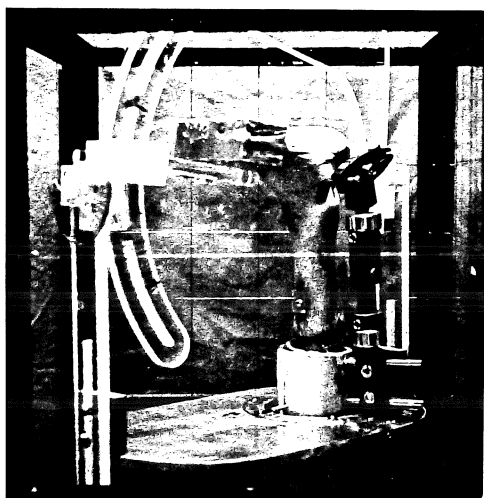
The test apparatus in the calibration frame used for biplanar radiographic analysis.
